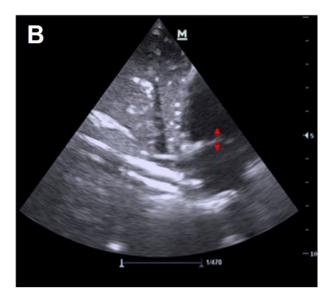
The Echocardiography on the second day of hospitalization. The arrow in A indicates a Left Ventricular End-Diastolic Diameter (LVEDD) of 37.5 mm, while the arrow in B indicates a Tricuspid Annular Plane Systolic Excursion (TAPSE) of 8 mm
